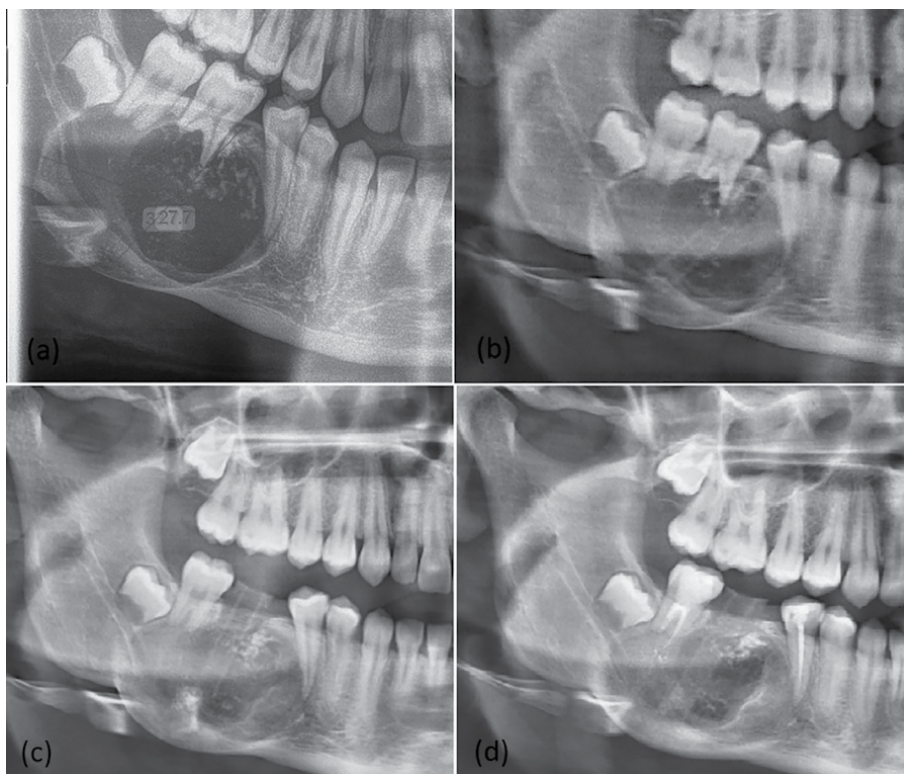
Decompression in a pediatric patient with unicystic ameloblastoma of the mandible. Preoperative radiographic follow-up (surgical procedure is presented in Figure 7): (a) initial situation of a large ameloblastoma; (b) 2 months after rubber tube insertion; (c) 4 months after tube insertion; and (d) 9 months after tube insertion.
